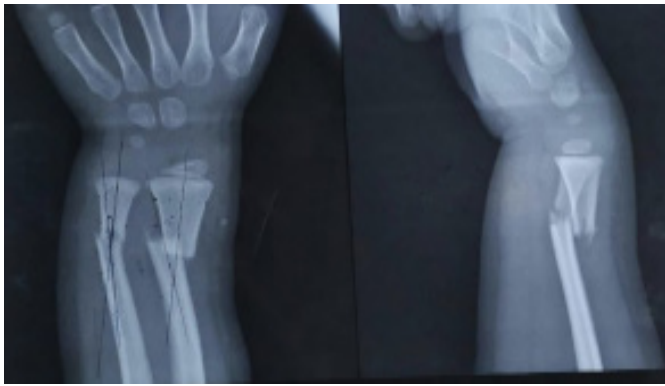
Initial post-trauma radiograph
